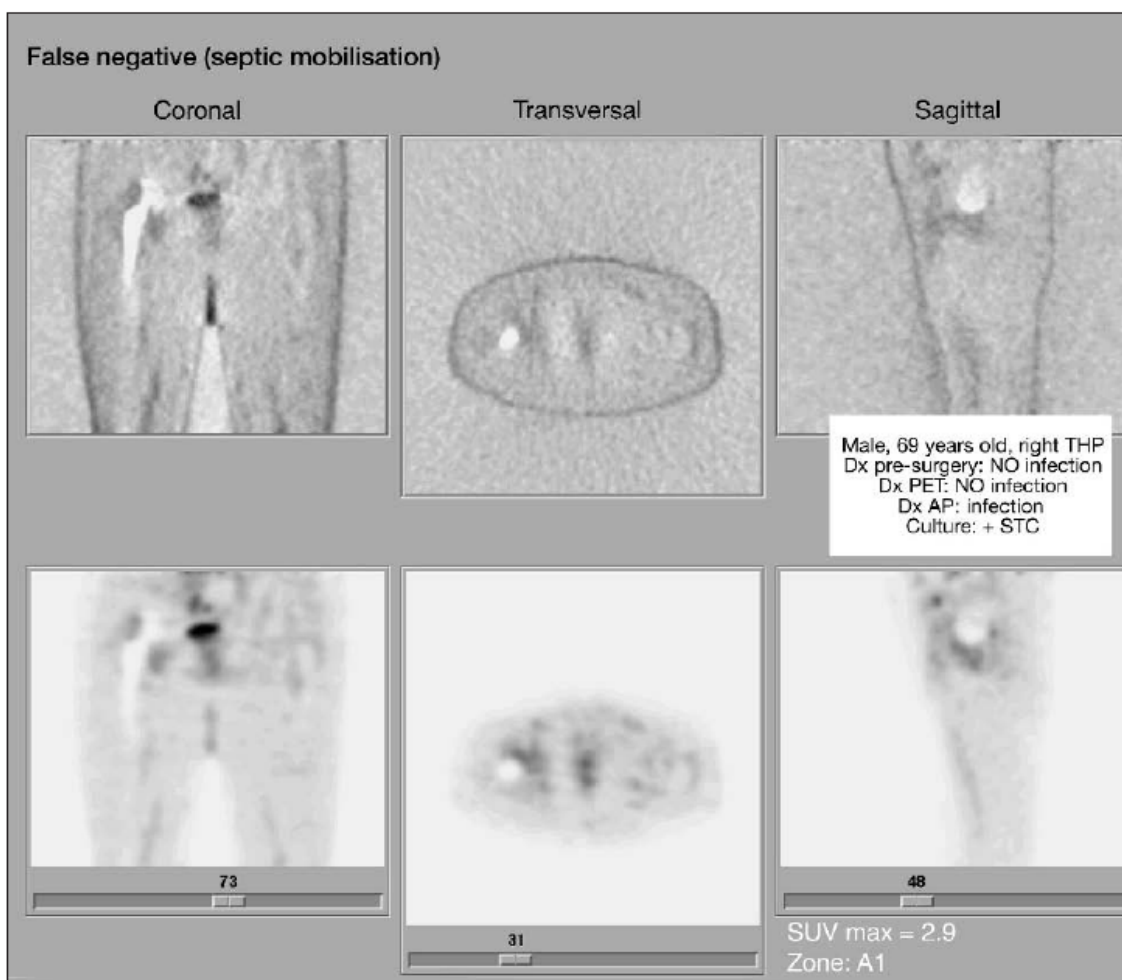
False negative on positron emission tomography (PET); case labelled as not infected by PET imaging and which was. THP: hip prosthesis; SUVmax: maximum standardised uptake value.
